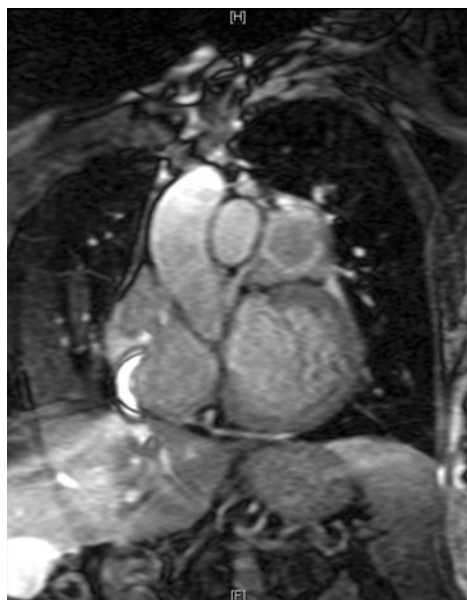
MRI of Castleman tumor.
